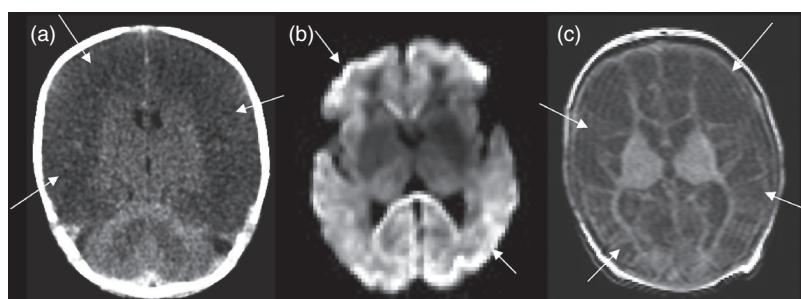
Very severe partial prolonged HIE: acute–subacute phase with (a) low-density cerebral peak edema (arrows) on axial CT and (b) high-intensity cerebral restricted diffusion (arrows) on axial DWI; (c) chronic phase with cystic encephalomalacia (arrows) on axial T1.
